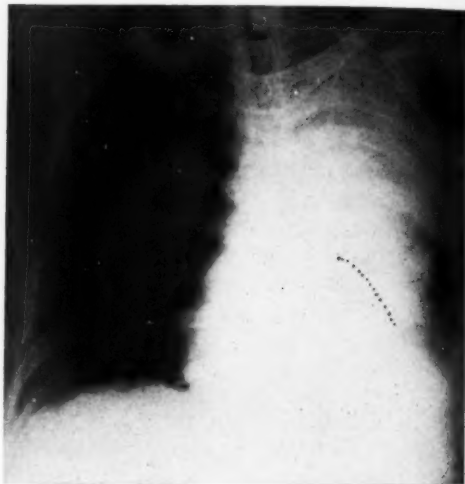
Roentgenogram made March 27, 1940, seven months after roentgen therapy. The consolidation of the upper half of the left lung is obvious. There is blunting of the left costophrenic angle. The right lung remains clear. There is no displacement of the trachea. The fullness of the cardiac shadow is clearly seen to the right as compared with the earlier film (Fig. 1). The left cardiac border cannot be clearly seen in this reproduction, but a dotted line has been used to show its location on the original film. The enlarged cardiac shadow was noted only in retrospect. The bony thorax is still intact. (Note in this and the subsequent reproductions the descent of the leaves of the diaphragm as the patient loses weight.)
